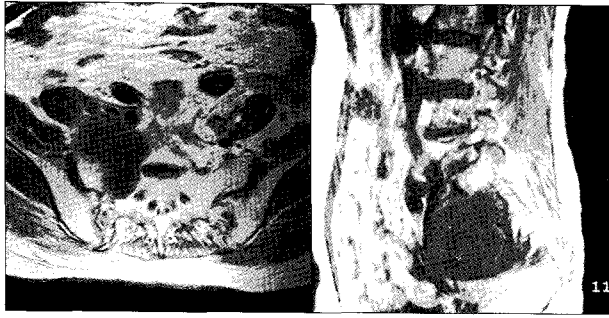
The pelvic magnetic resonance image showing 5.5×7 cm sized partially enhancing heterogenous mass which is eroding the sacral bone and widening the right S1 neural foramen.
